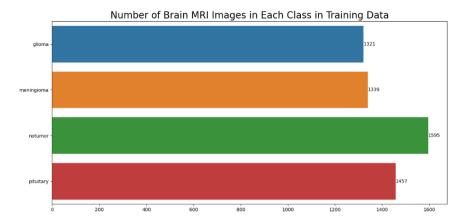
Number of Brain MRI Images in Each Class in Training Data
